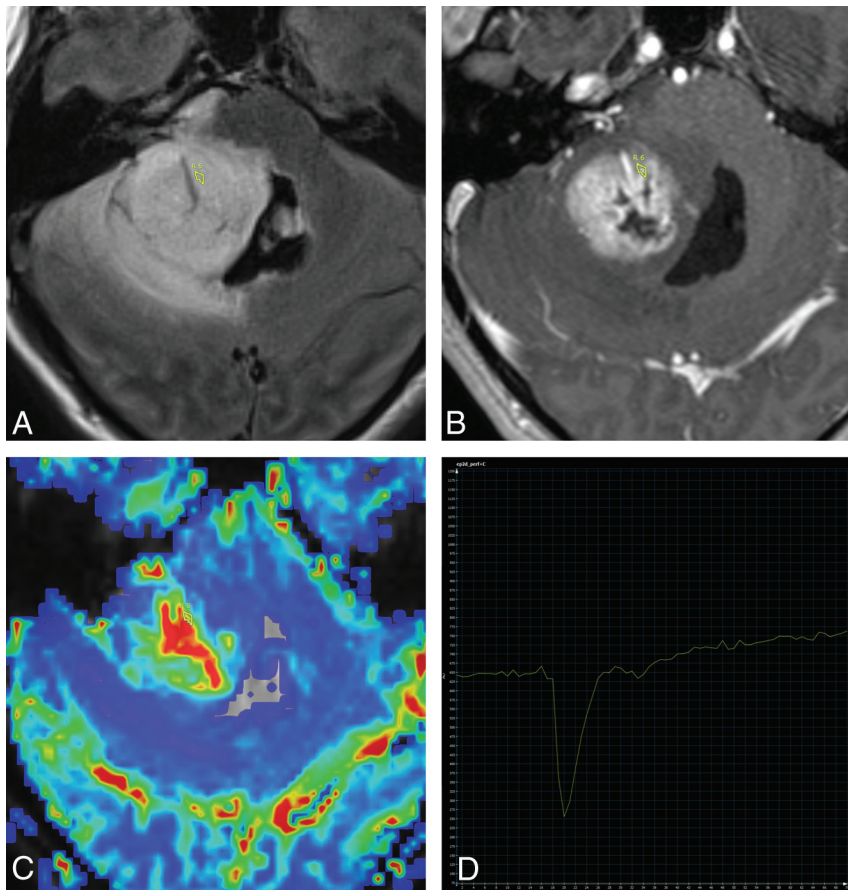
Axial T2 FLAIR (A), axial T1-weighted postcontrast (B), axial DSC perfusion rCBV map (C), and tissue signal-intensity time curve (D) of a pilocytic astrocytoma with atypical appearance. Despite apparent increased rCBV, poorly defined margins, central necrosis, and surrounding T2 hyperintensity suggesting a high-grade neoplasm, the T1-dominant leakage pattern suggests the correct interpretation of a low-grade tumor. The ROI is placed in the highest perfusing portion of the tumor, not including a dominant central vessel.
